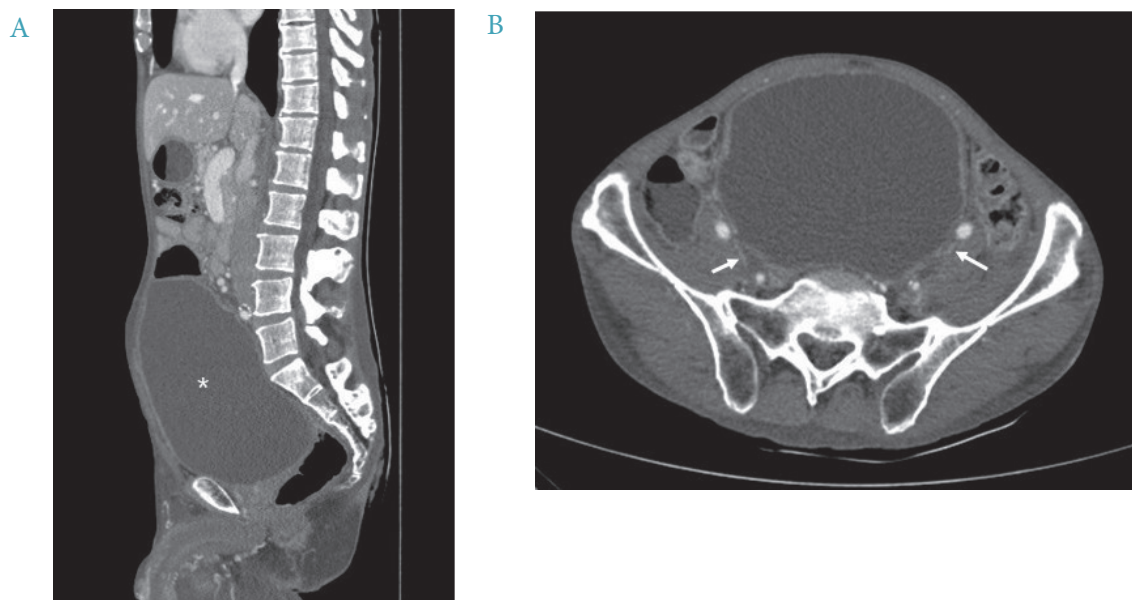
Computed tomography of abdomen and pelvis showing massive enlarged bladder (*), sagittal view (1A) with compression of both external iliac veins (arrows), axial view (1B).
